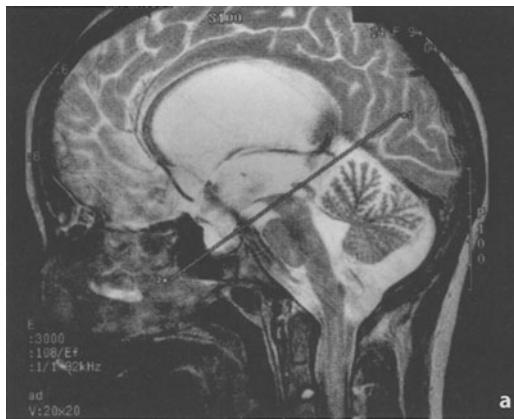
A 14-year-old boy with aqueductal stenosis treated with third ventriculostomy. a Sagittal T2-weighted MRI shows flow void in the region of the ventriculostomy. b Quantitative measurement of flow through the ventriculostomy proves the patency of the internal shunt
